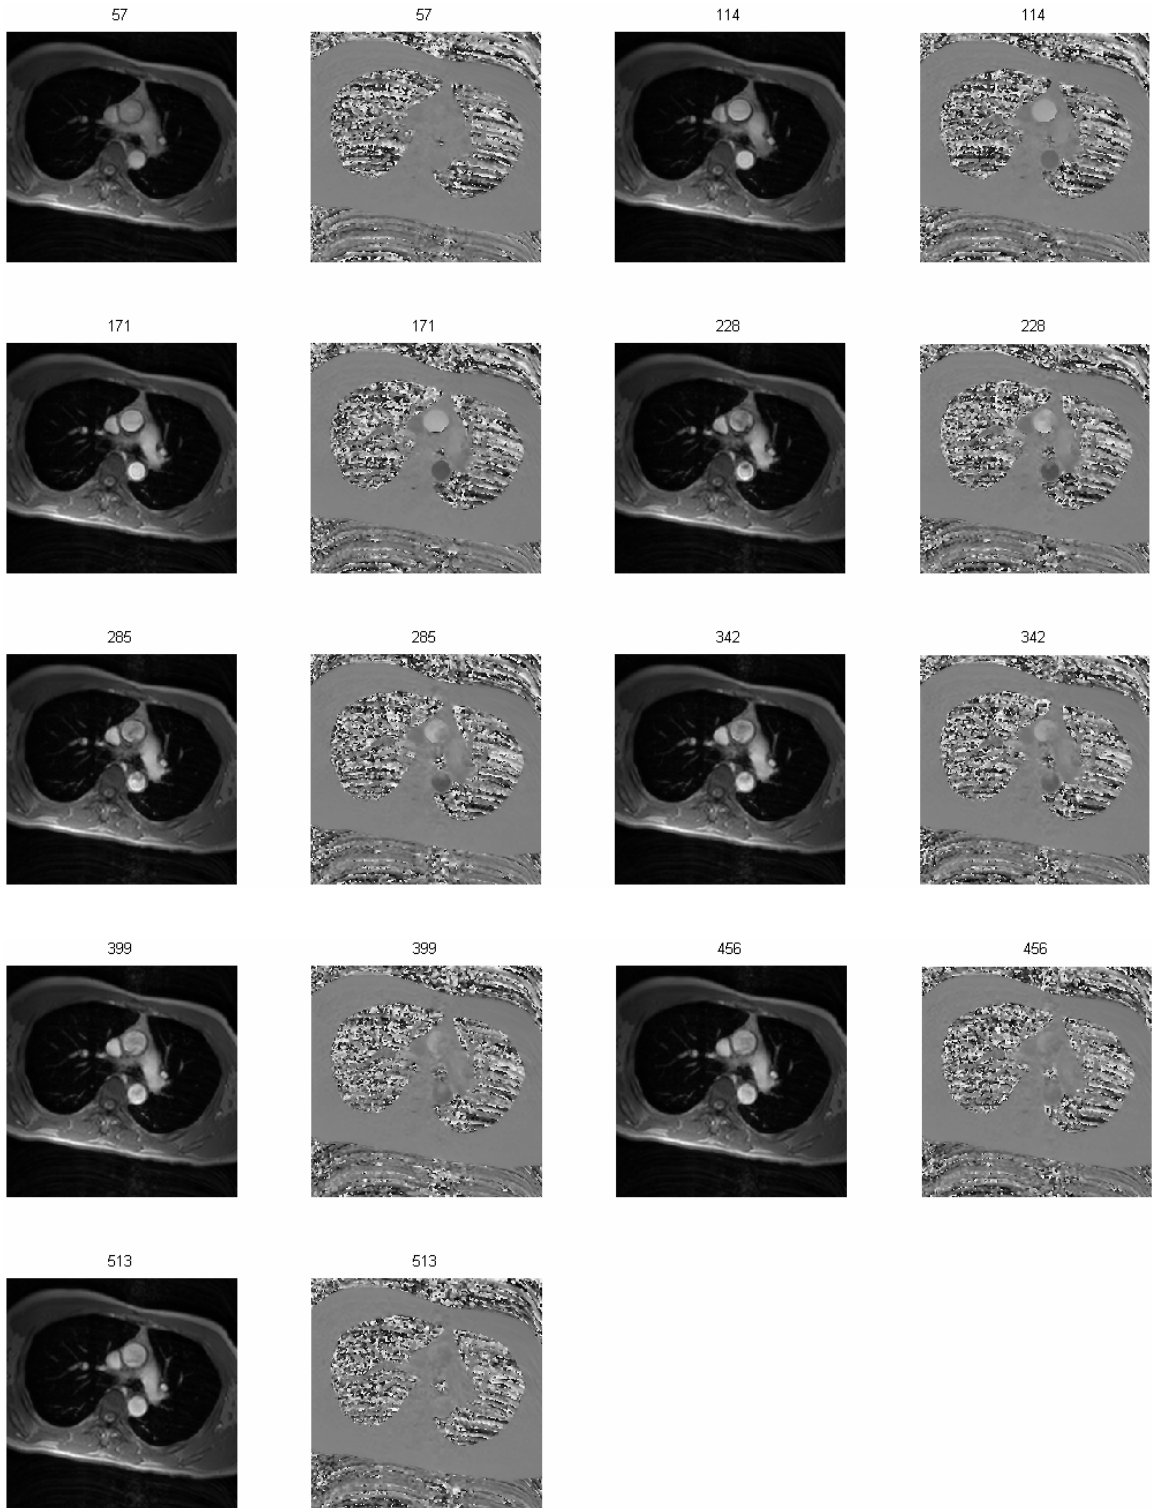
PC-MRI slices for the axial velocity component in the inlet section - field of view, 300×300 mm; image resolution, 256×256 pixels; slice thickness, 6 mm. The slices include 20 images to cover one cardiac cycle.
